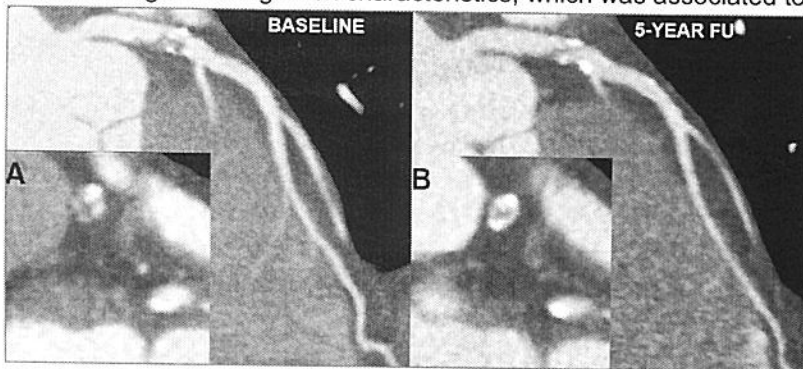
Coronary computed tomography angiography of left anterior descending artery with curved multi-planar
